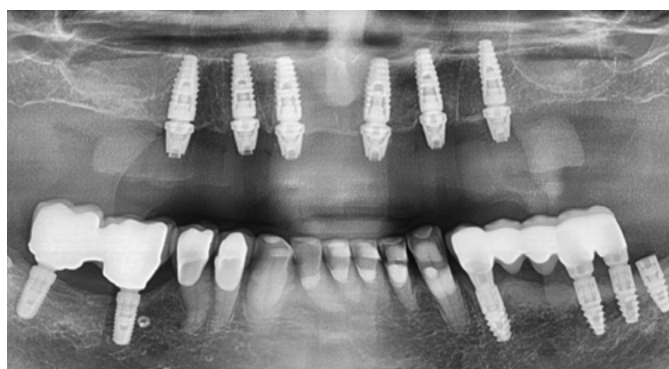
Post-op panoramic x-ray
